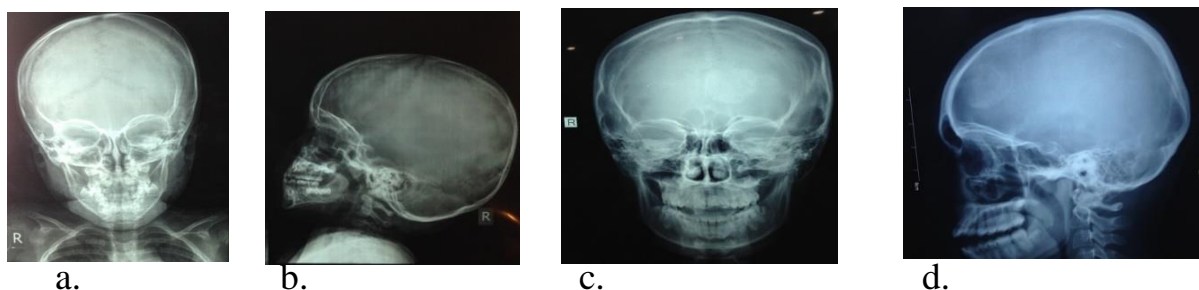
Case 1. Plain skull X-ray films. a. Postero-anterior view showing left sided parietal bone bulging, a bony deformity due to long standing HC lesion growth. b. Lateral view showing coronal sutural diastasis. c. Postero-anterior view showing calcification. d. Lateral view showing calcification.
